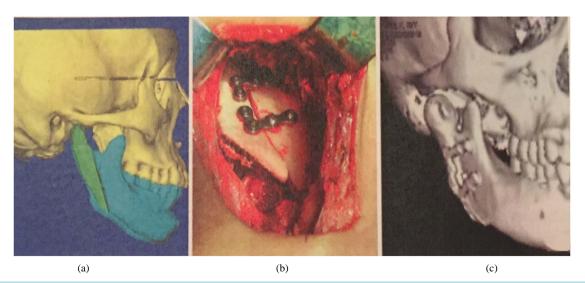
(a) Display showing orientation of the implant; (b) inserted implant into defective area and fixed using miniplates; (c) computed tomography scan showing the condylar defect reconstructed 28 days after operation [11].
